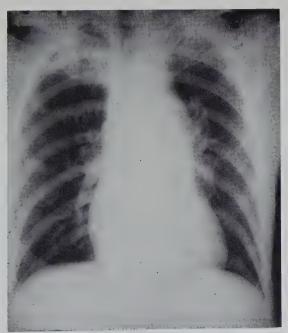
Anteroposterior roentgenogram of chest shows a widened superior mediastinum. Aortography proved the widening to be due to a ruptured thoracic aorta at the isthmus.
